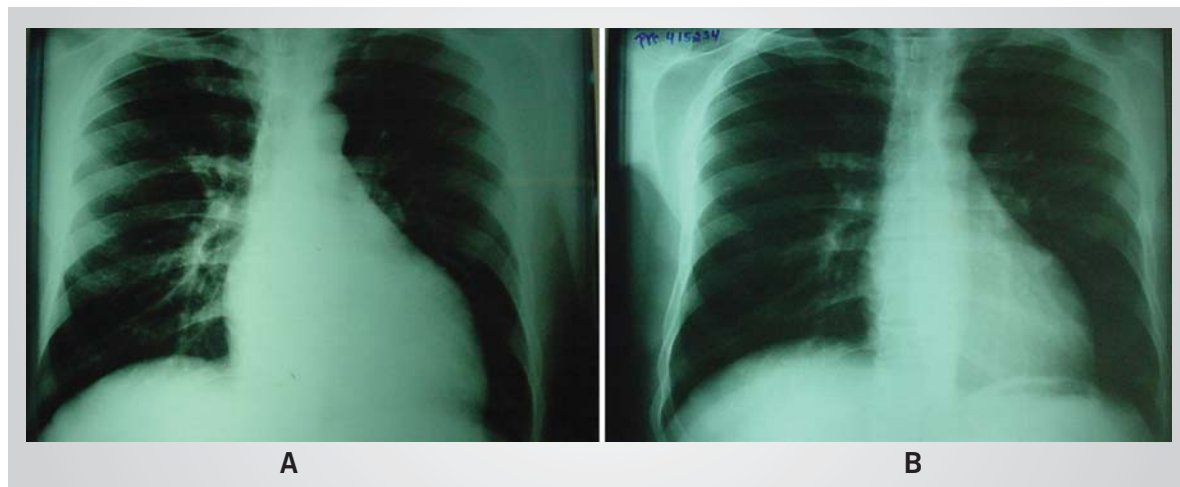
PA thorax X-ray before (A) and after (B) cell therapy
